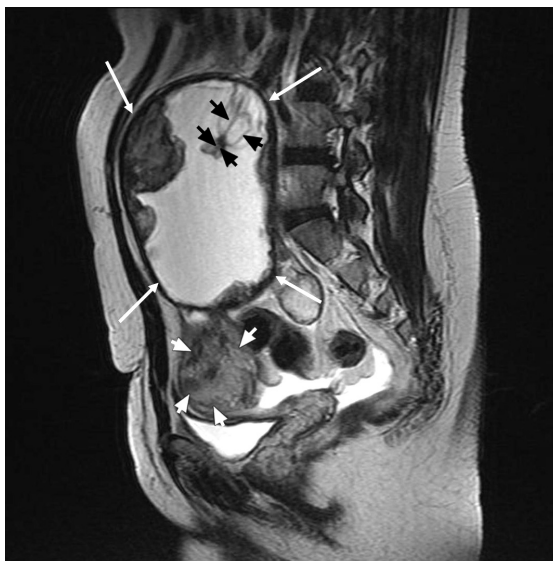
Sagittal T2-W MR image of the pelvis shows a mass (white arrows) containing solid internal components (black arrowheads). Part of the normal left uterine fundus (white arrowheads) is visible above the urinary bladder.
